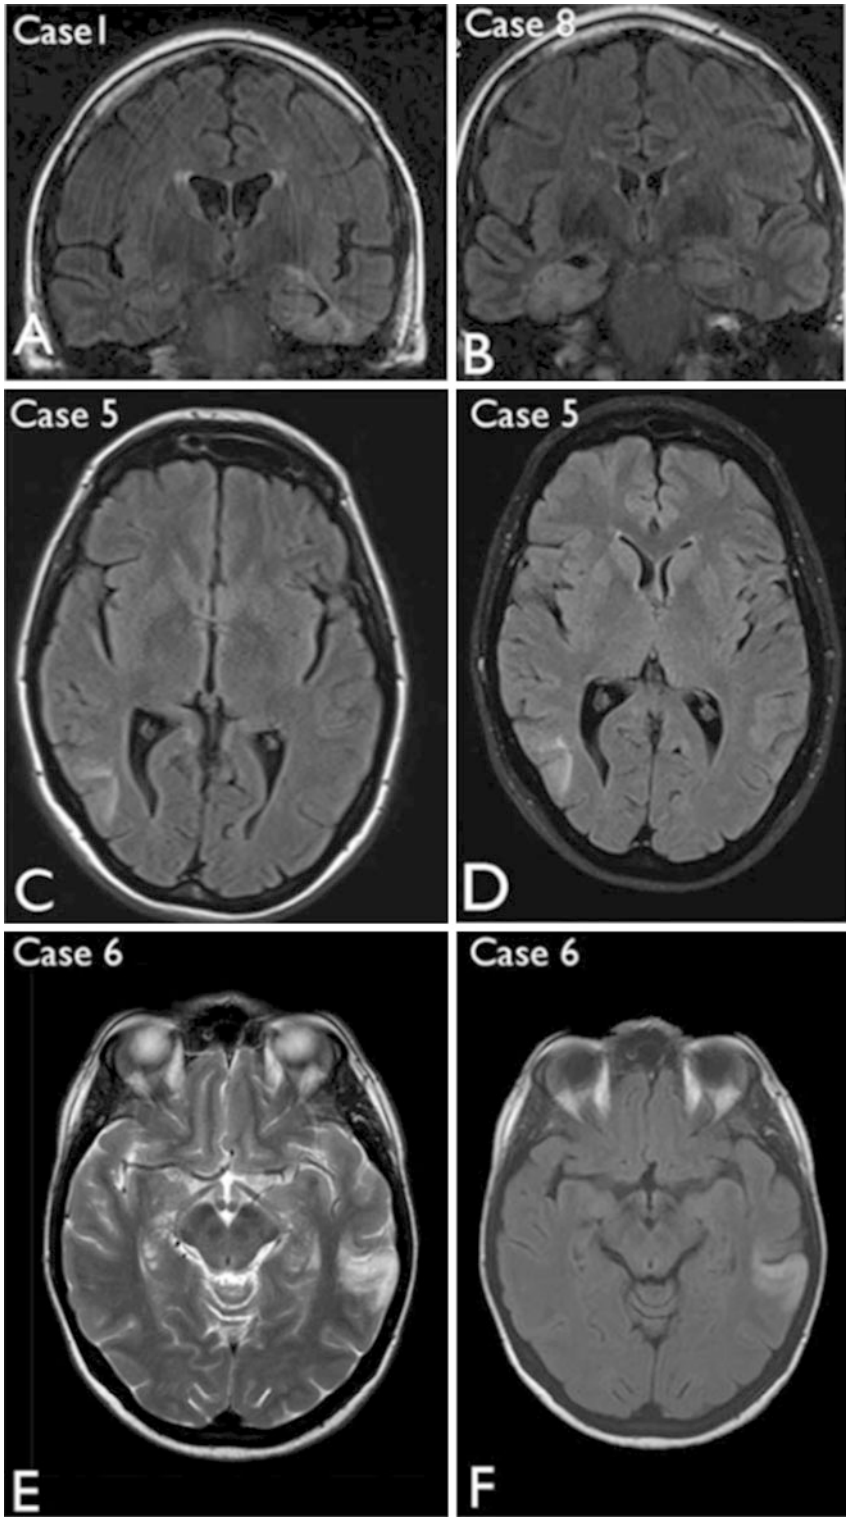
Multinodular vacuating glioneural tumor, several case examples on FLAIR (a–d, f) and T2 w (e) imaging with permission from Thom et al. (2018)
